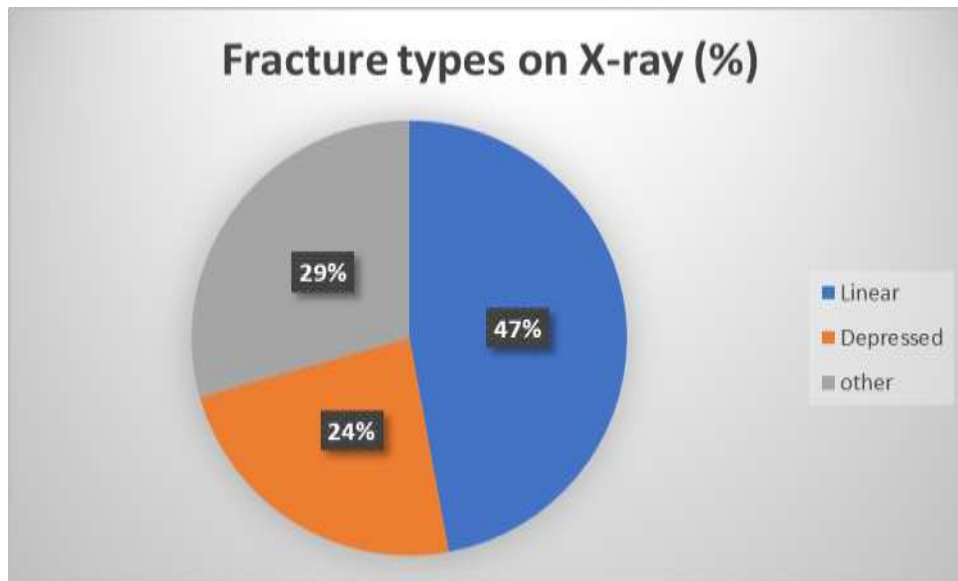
clearly demonstrates that linear fractures constitute the vast majority, at 47% of the skull fractures in this elderly patients. Depressed fractures (24%) and comminuted/other fractures (29%) make up the remaining third, this strongly suggest that most linear skull fracture pattern of the skull bone are easily seen on normal skull radiograph and that it frequently occurs likely because it is caused by low-energy impact like fall and mild accident, also depressed fracture pattern appear to be less prevalent likely because it is mostly caused by severe accident or blunt force trauma which is less likely in older patients, also others which includes various other fracture pattern having a high value because of the wide range of fracture pattern to evaluate
